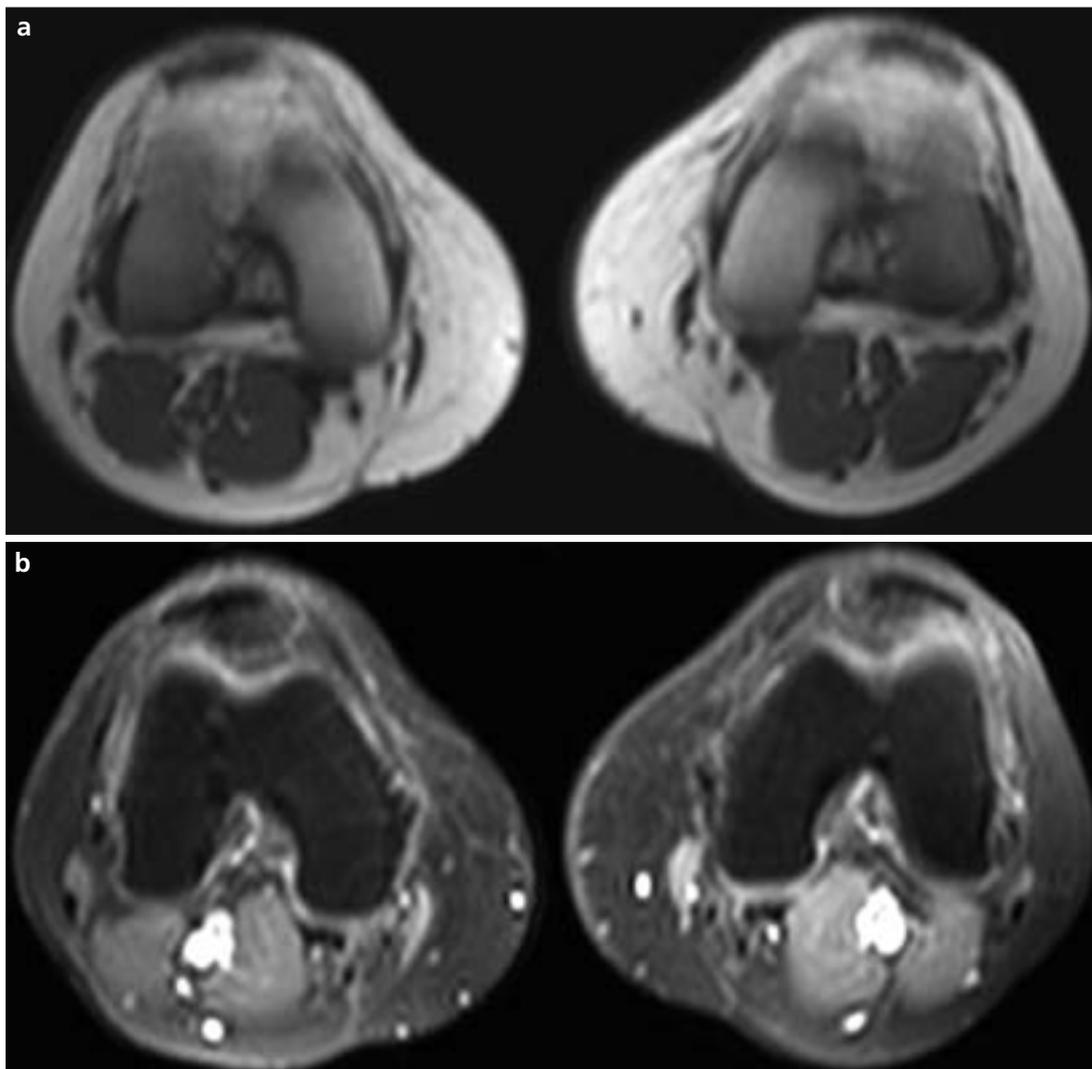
a, b. Axial plane non-enhanced T1-weighted (a) and gadolinium-enhanced fat-suppressed T1-weighted MR images (b) do not reveal any pathology.
